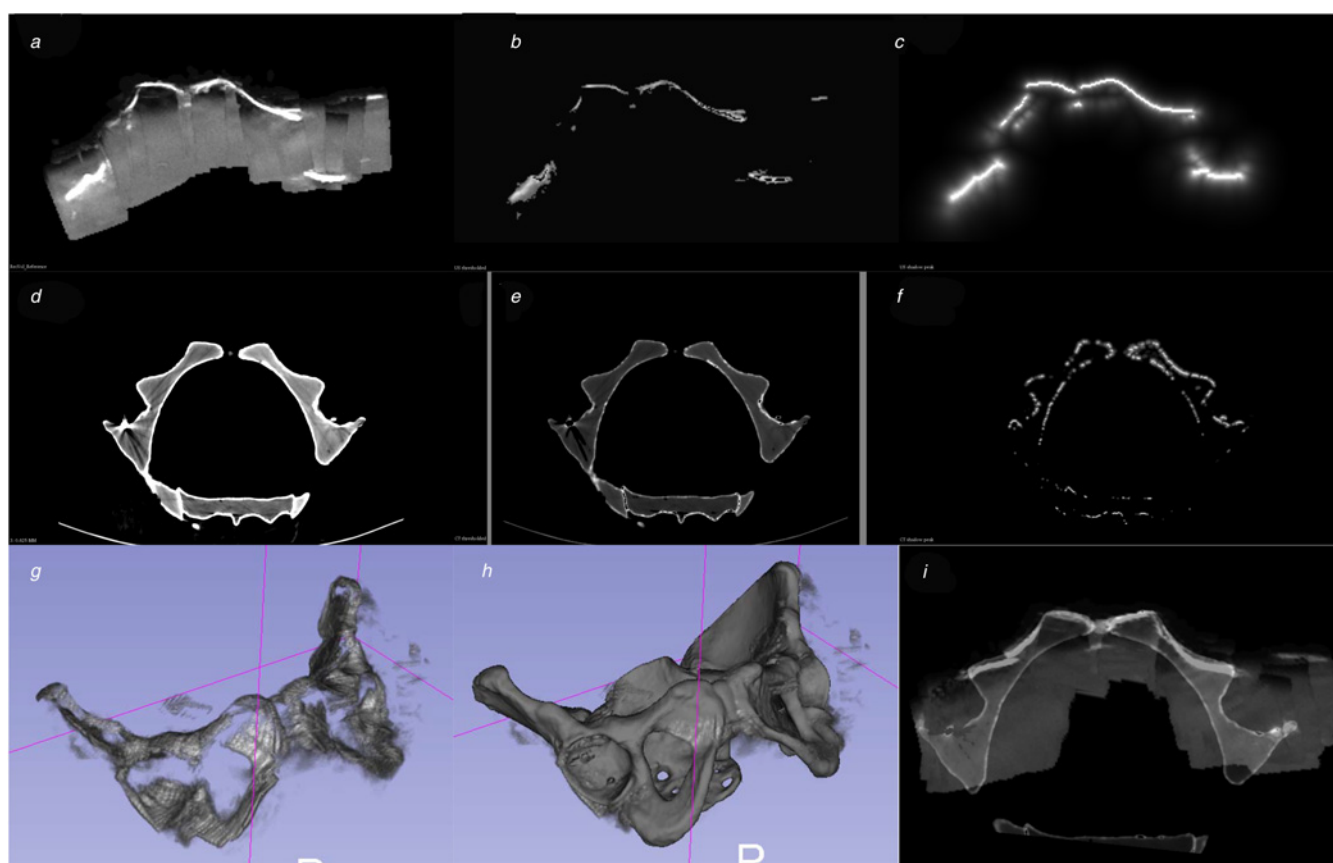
CT to US registration steps
